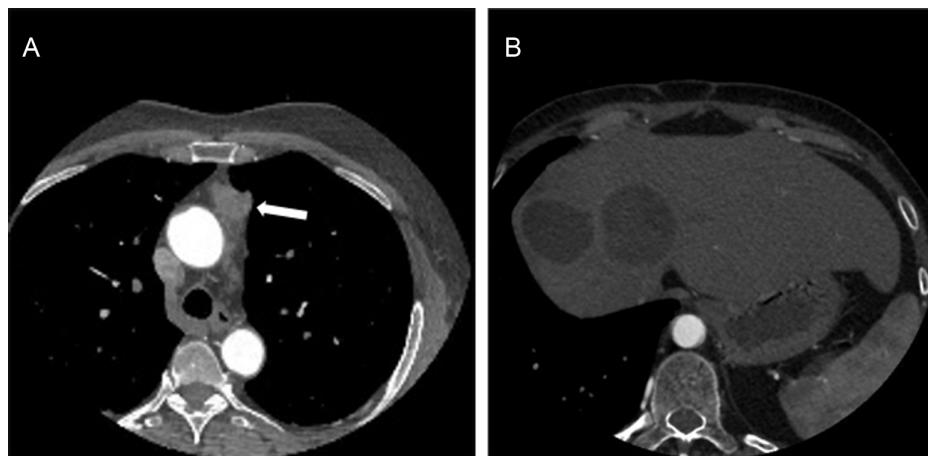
Two examples of noncardiac findings identified on axial CCTA. (A) Anterior mediastinal mass with soft tissue density (white arrow). This lesion was confirmed to be neuroendocrine tumor after surgical resection. (B): Two hydatid cysts at the level of the liver. CCTA, coronary computed tomography angiography.
